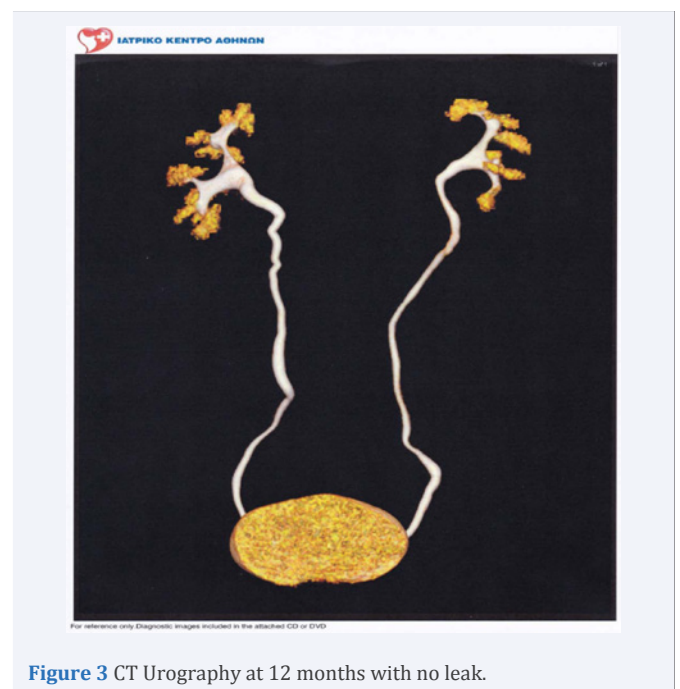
CT Urography at 12 months with no leak.
